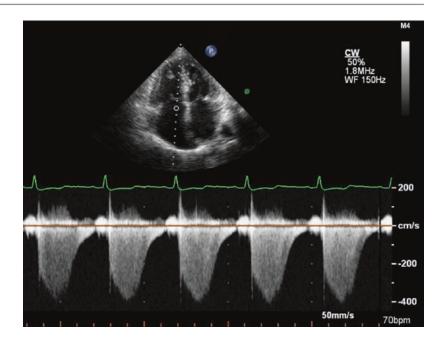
Continuous wave Doppler in the same patient as Fig. 2.19 showing the entire spectral display without aliasing so that the peak systolic velocity can be measured
